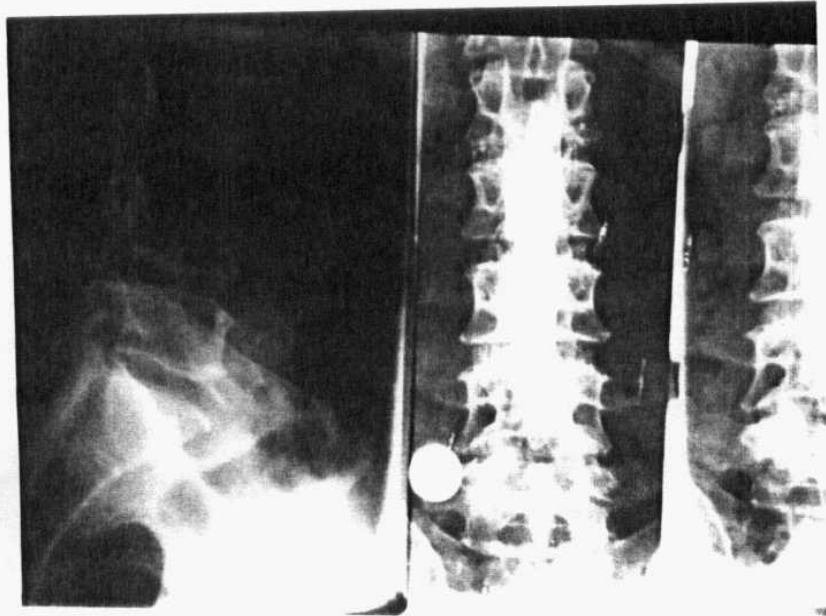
Myelography of a man showing complete obliteration of the dye opposite L45. This obliteration gives no idea about the disc condition distal to this obliteration of the dye. By using MRI the presence of another disc at L5S1 detected.
